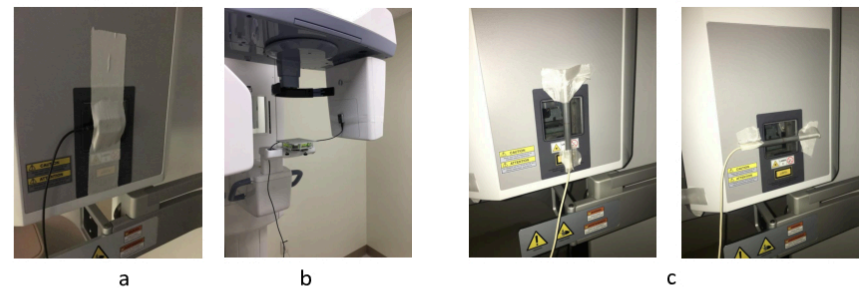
Three methods for measuring the CBCT dose or air kerma. (a) solid-state small-area dosimeter at x-ray window (b) solid-state small-area dosimeter at geometric center of image receptor (c) 100mm long CT ionization chamber positioned vertically and horizontally
